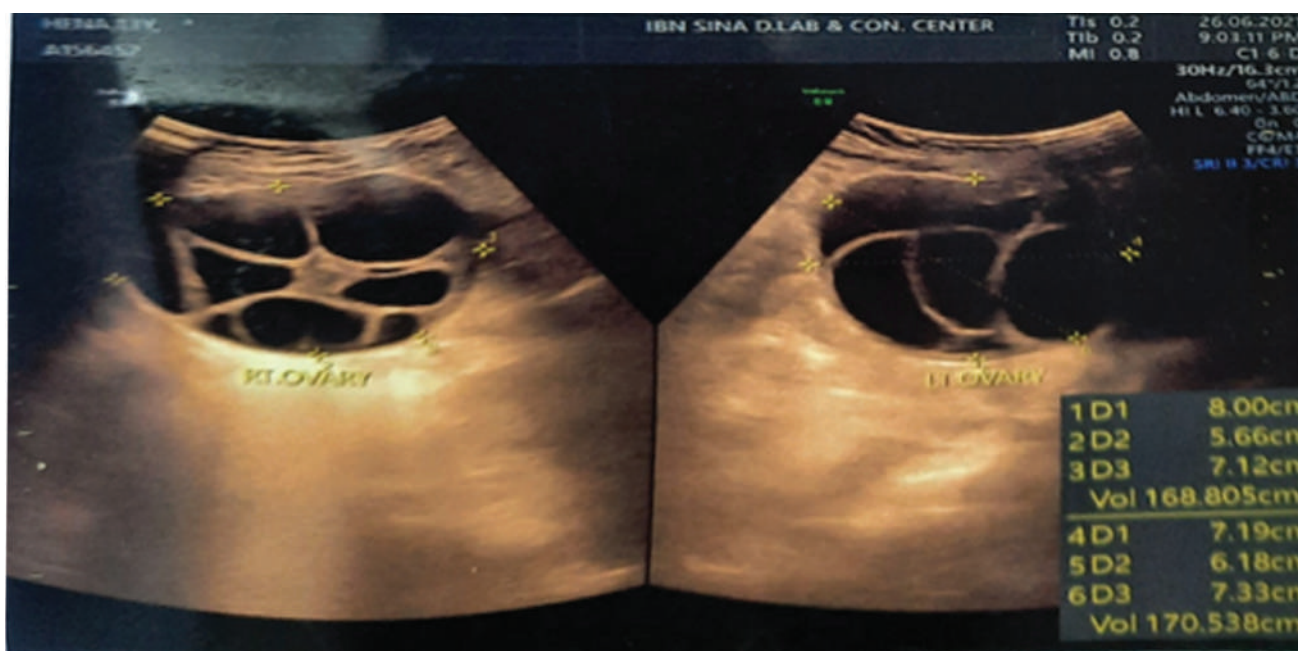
Ultrasonography shows soap-bubble or wheel-spoke appearance in both the ovaries
